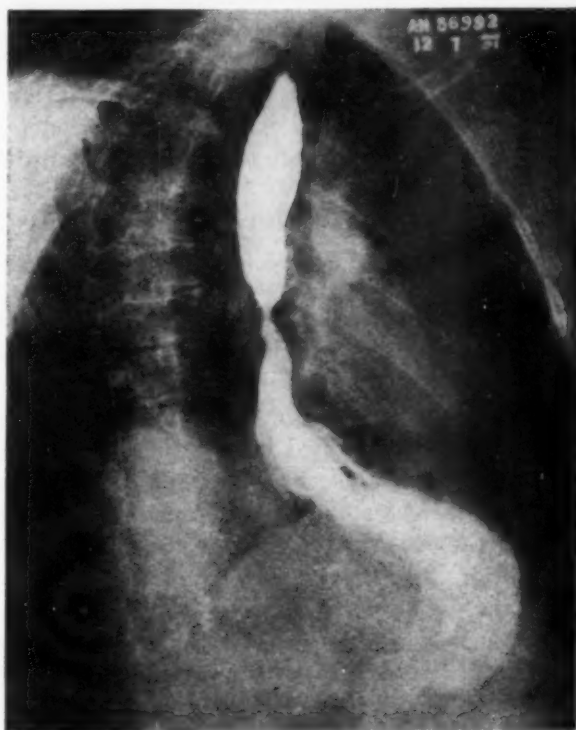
Case of a man 72 years of age who for two years had some disturbance in swallowing. Recently, substernal pain radiating through to the back developed and distressed the patient most while he was lying down. The radiographic findings are not unlike those of congenital short esophagus with a portion of stomach in the thoracic cage and stenosis at the esophagogastric junction. The esophagoscopic findings were dilatation of the esophagus with marked narrowing of the food passageway, the presence of superficial ulceration of the mucosa at the point of narrowing in the thorax, and the presence of gastric mucosa beyond the stenosis. This was believed to be a hiatal hernia of long duration, with ulceration at the esophagogastric junction which ultimately resulted in cicatricial changes. The patient subsists chiefly on soft foods and gets along well with three or four esophagoscopic dilatations and topical applications of silver nitrate 5 per cent to the ulcerated area annually.
